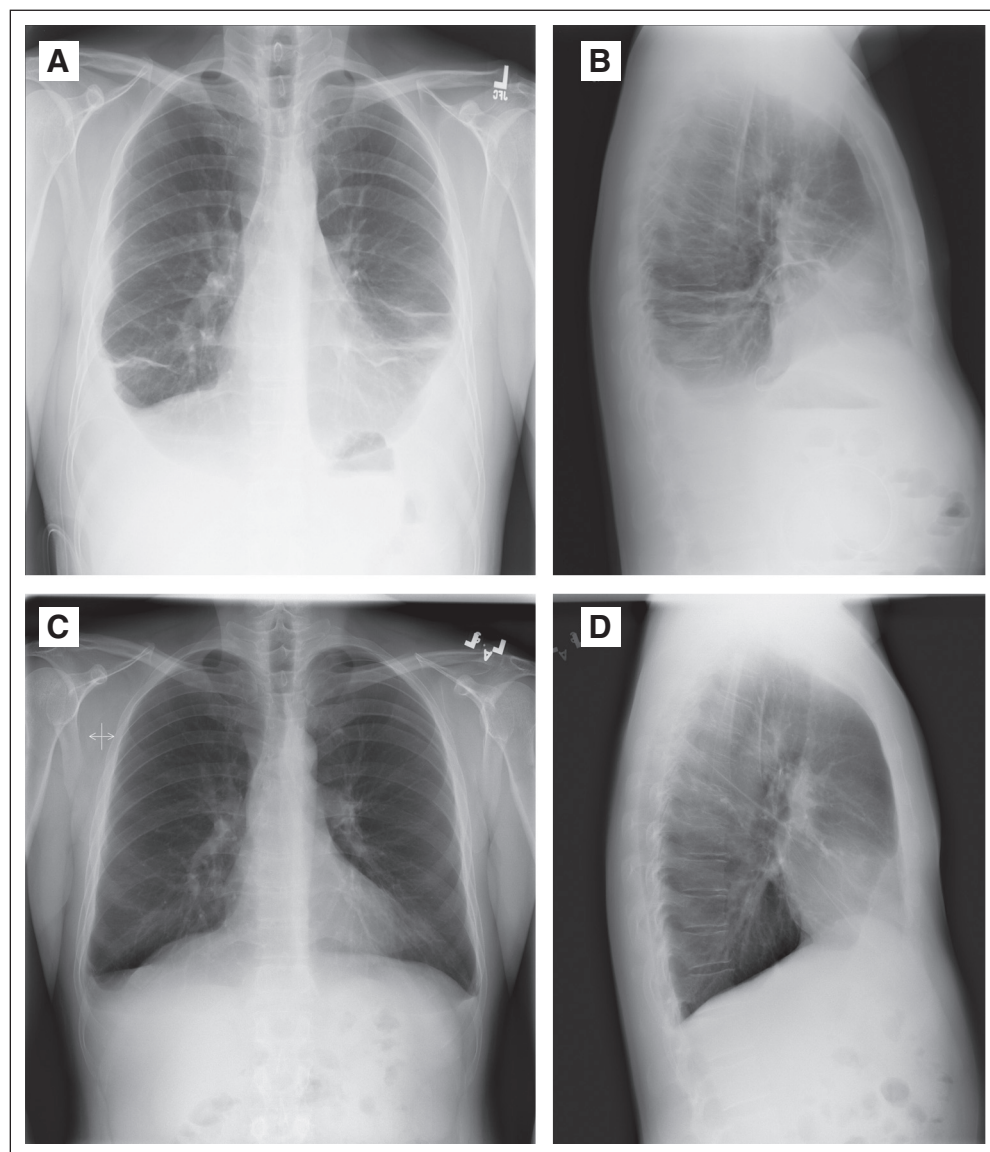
Resolution of a Kaposi's sarcoma (KS)-associated chylothous pleural effusion in a patient receiving bevacizumab. A 44-year-old man with HIV and KS had dramatic worsening of KS after starting highly active antiretroviral therapy, with development of greater than 50 cutaneous lesions, KS involving pelvic and inguinal lymph nodes, bilateral pleural effusions draining up to 6 L a week, and bilateral lower extremity edema. Analysis of the effusions did not reveal evidence of primary effusion lymphoma. The patient received 10 cycles of liposomal doxorubicin with some improvement in cutaneous lesions but no resolution of effusion, which required a right-sided indwelling pleural catheter. He also had continued lower extremity edema requiring daily diuretics. Within the first two cycles of bevacizumab, the effusions stopped draining, lower extremity swelling resolved, and diuretics were discontinued. (A) Posterior-anterior and (B) lateral chest x-rays at baseline. Bilateral pleural effusions and indwelling pleural catheter are on right. Pleural fluid was chylothous (effusion triglycerides 1,905 mg/dL). (C) Posterior-anterior and (D) lateral chest x-rays at month 3 on bevacizumab. The effusions are resolved, and the indwelling catheter has been removed.
